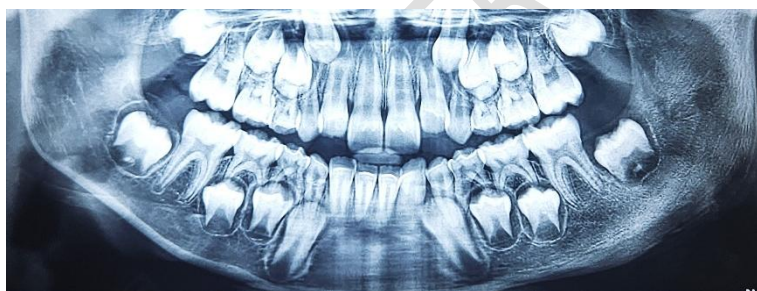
Orthopantomograph showing mixed radiolucent–radiopaque lesion in the left second mandibular premolar–ramus region.
